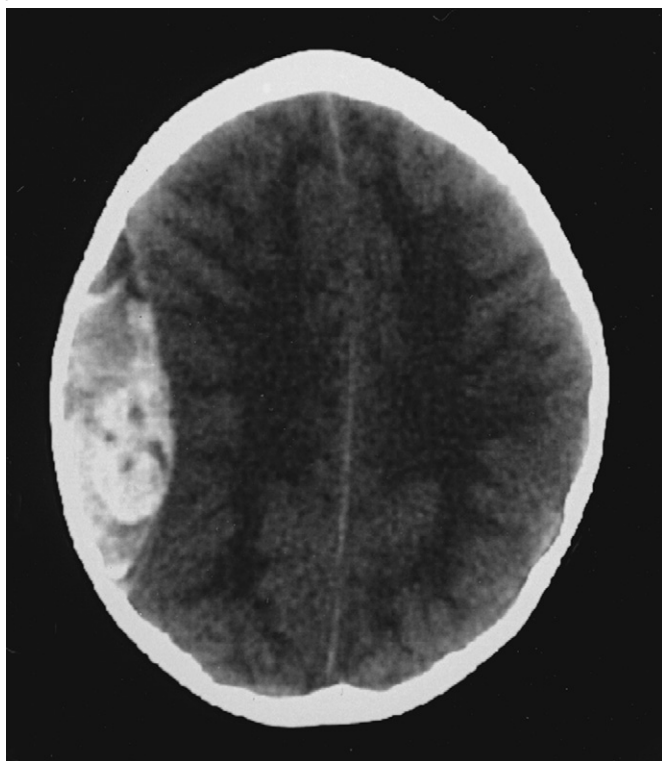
Non-contrast-enhanced computed tomography scan of acute epidural hematoma at the level of right midconvexity. There is an associated mass effect and moderate midline shift.
